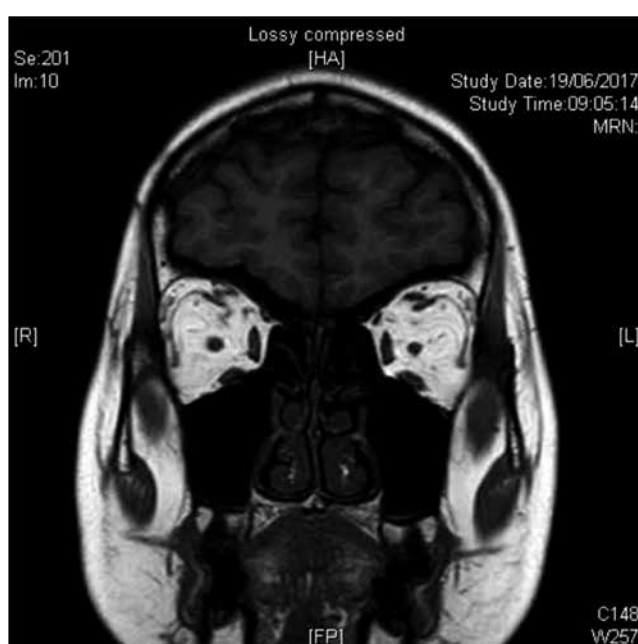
Magnetic resonance imaging showing normal-sized extraocular muscles with fat expansion
